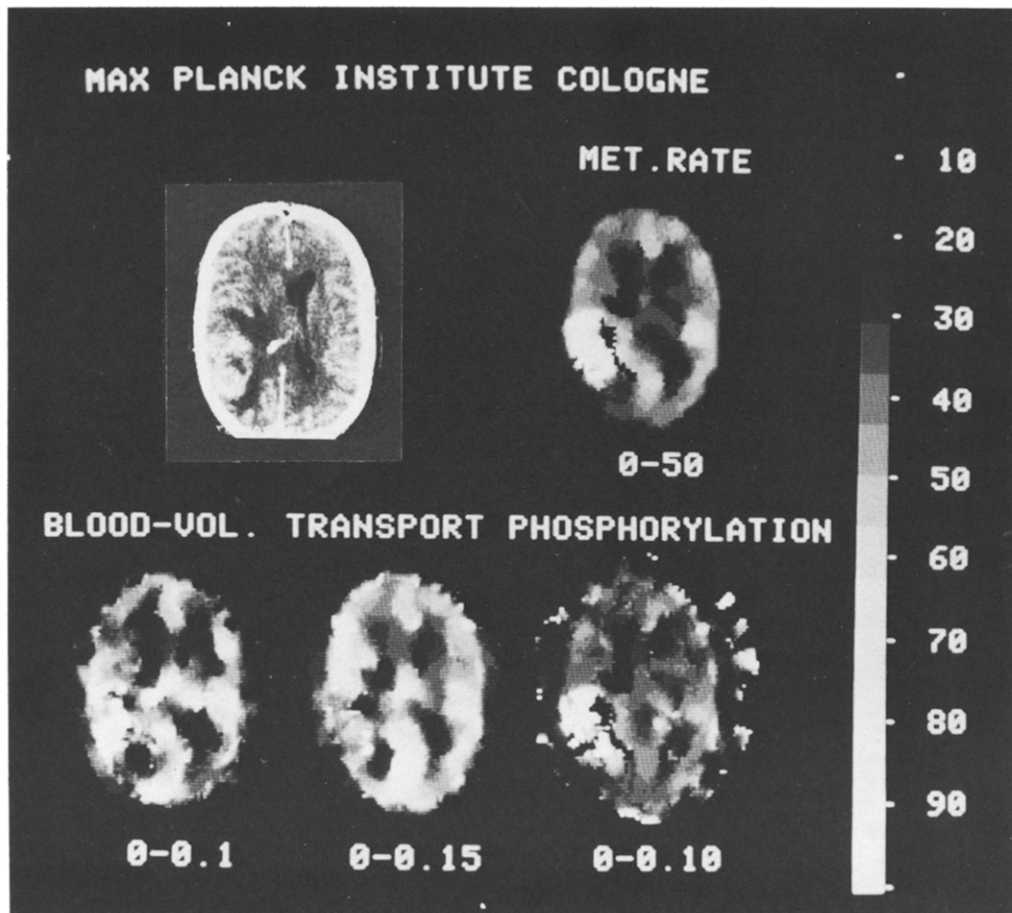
X-Ray CT with i.v. contrast material (top row, left) and parametric FDG-PET images (glucose metabolic rate in $\mu\text{mol}/100 \text{ g}/\text{min}$, local blood volume in ml/g , transport rate constant K_1 in $\text{ml}/\text{g}/\text{min}$, and phosphorylation rate constant k_2 in $1/\text{min}$) of a right temporal glioblastoma (patient 15) with hypermetabolic, contrast enhancing rim around central necrosis. Good vascularization but normal or even slightly decreased FDG transport in hypermetabolic area. Value ranges are displayed below each image; the gray scale numbers indicate percentage values of individual range. Patient's left is on viewer's right.
